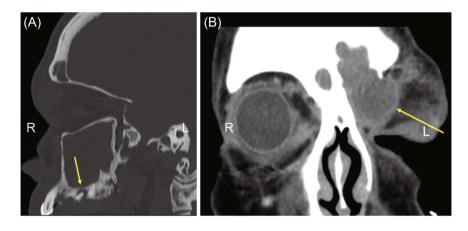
Example of odontogenic sinusitis causing an orbital subperiosteal abscess, resulting in left orbital pain and proptosis but no vision loss. (A) Sagittal noncontrast computed tomography demonstrating complete maxillary and frontal sinus opacification and a maxillary premolar root with a periapical lesion and bone erosion (yellow arrow). (B) Coronal computed tomography with contrast demonstrating left frontal sinus opacification and sinus floor erosion, and a superiorly based rim-enhancing subperiosteal orbital abscess (yellow arrow)
